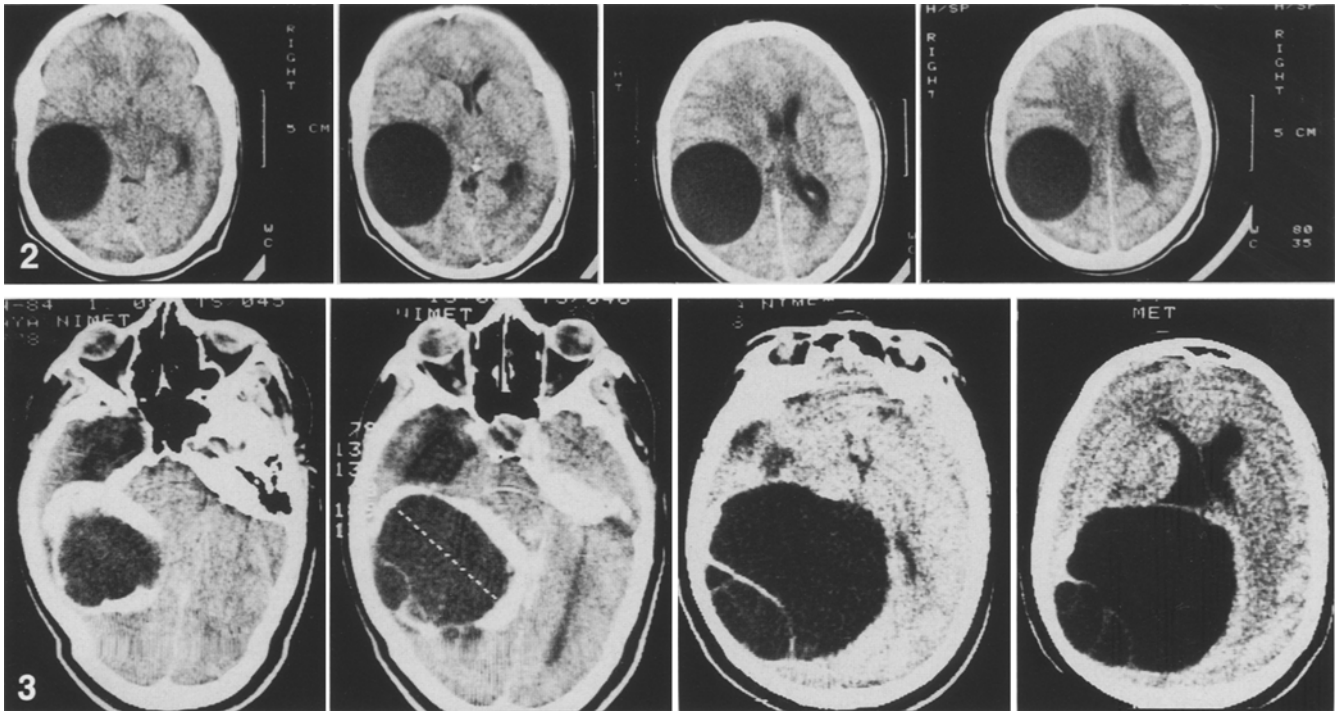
Typical appearance of cerebral hydatid cysts. CT scan demonstrating a spherical, well defined unilocular cystic mass in the parietal lobe
